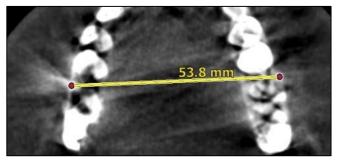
"IM" parameter: CBCT image in the axial plane.
